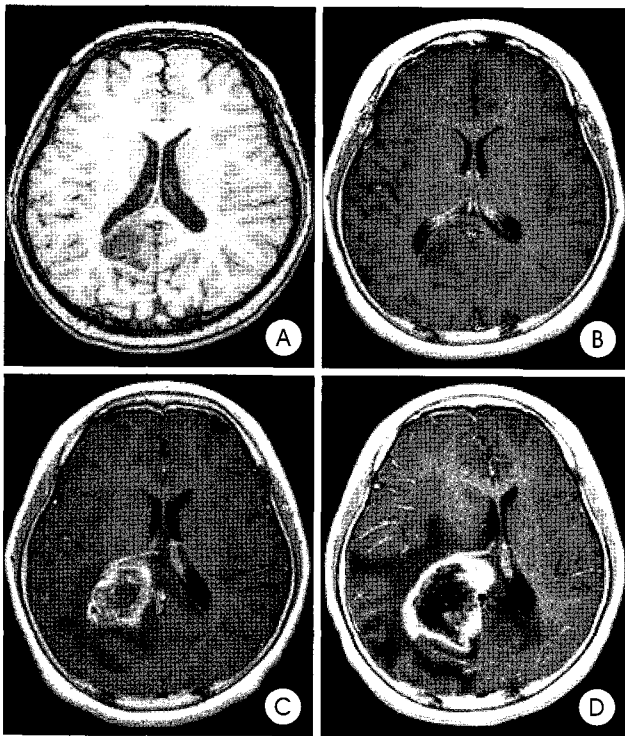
A : Non-enhancing mass in the right precuneus area and a signal defect due to previous stereotactic biopsy. B : Follow-up T1-weighted enhanced magnetic resonance (MR) imaging 7 months after Gamma Knife radiosurgery (GKS) showing no noticeable change. C : MR image 9 months after GKS showing enhancement combined with volume expansion. D : MR image 12 months after GKS showing tumor enlargement and peritumoral edema that needed microsurgical resection.
